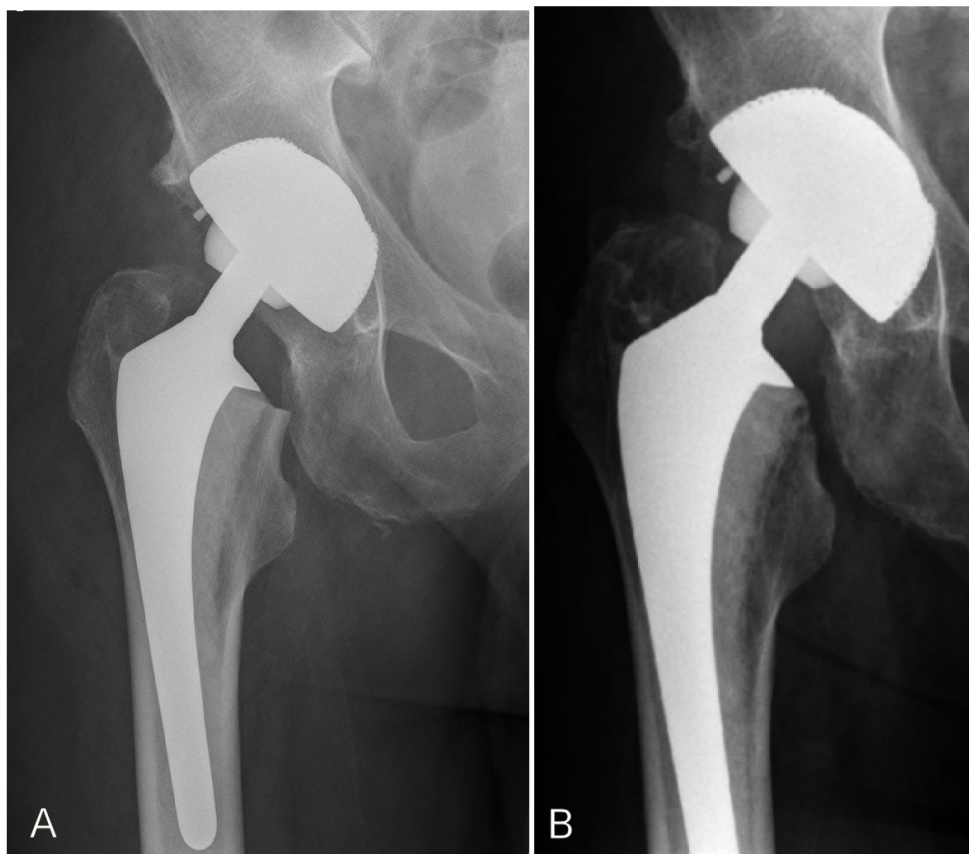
Postoperative X-ray of the right hip 4 days after operation (A) and 8 years later (B).
